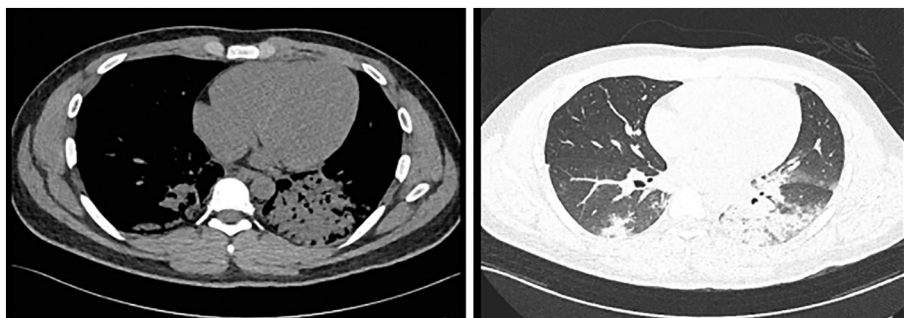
Chest CT scan demonstrates bilateral pulmonary infiltrates.
